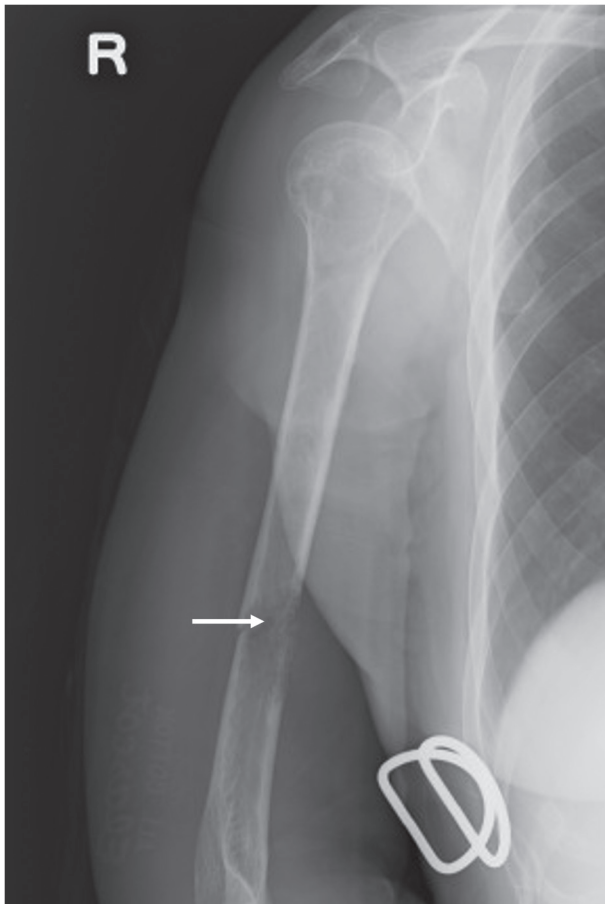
Radiographic examination of the right upper arm showing a pathological fracture caused by bone infiltration of the tumor.
